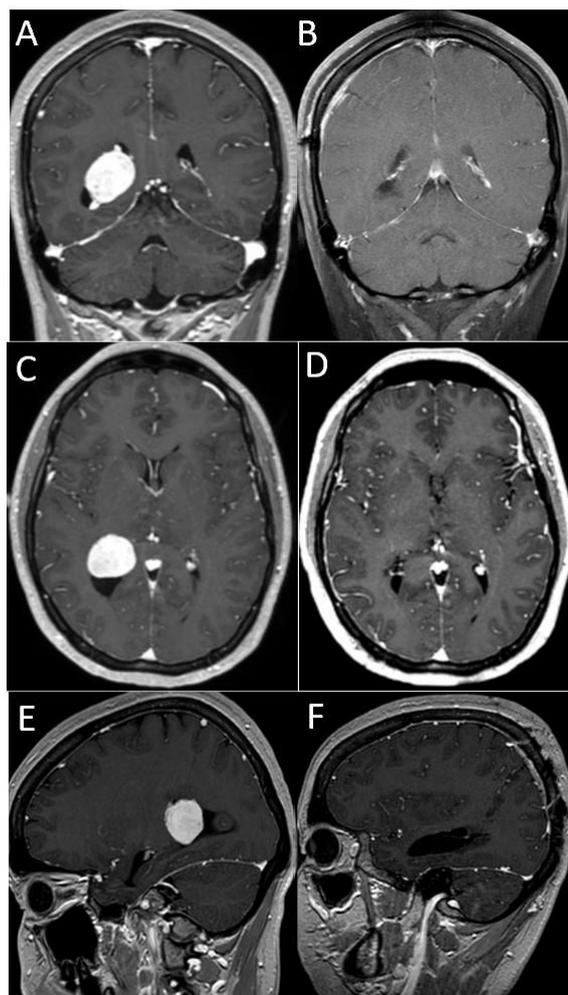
Resection of an intraventricular lesion utilizing BrainPath® from NICO corporation, Indianapolis, IN, USA. Post-contrast T1-weighted coronal (A), axial (C), and sagittal (E) sequences demonstrating a homogeneously enhancing lesion with the atrium of the right lateral ventricle. Post-contrast T1-weighted coronal (B), axial (D), and sagittal (F) sequences demonstrating gross total resection of the lesion with minimal disruption of the cortical and subcortical tissue in the region adjacent to the lesion due to the use of a minimally invasive surgical strategy with a tubular retractor.
